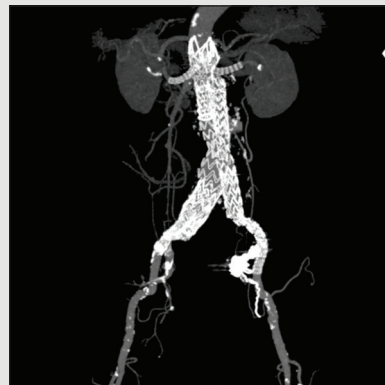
One-month postoperative CTA.
